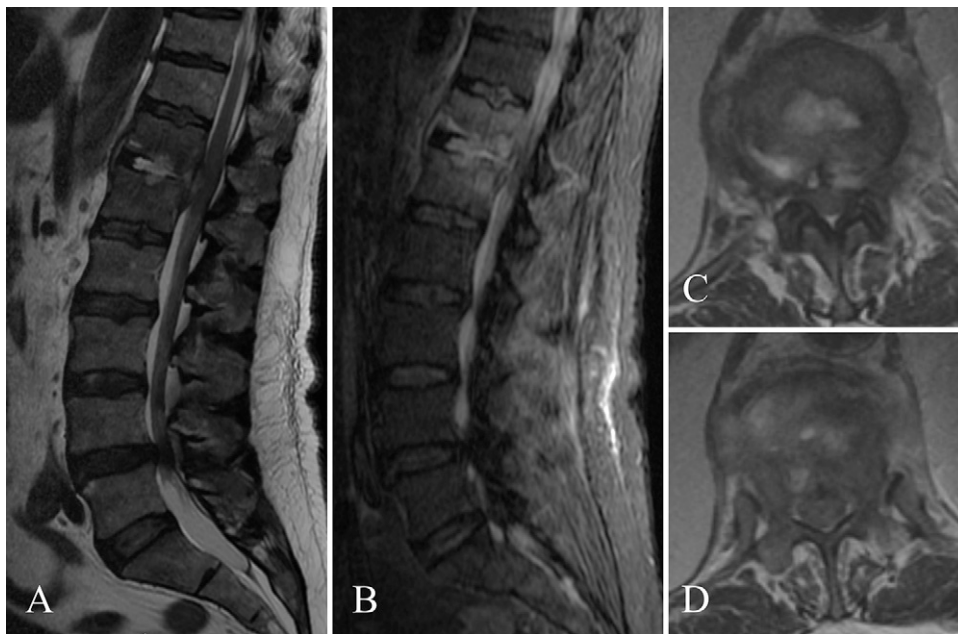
Sagittal (A and B) and axial (C and D) magnetic resonance images showing T12–L1 compromise with slight spinal canal involvement.
